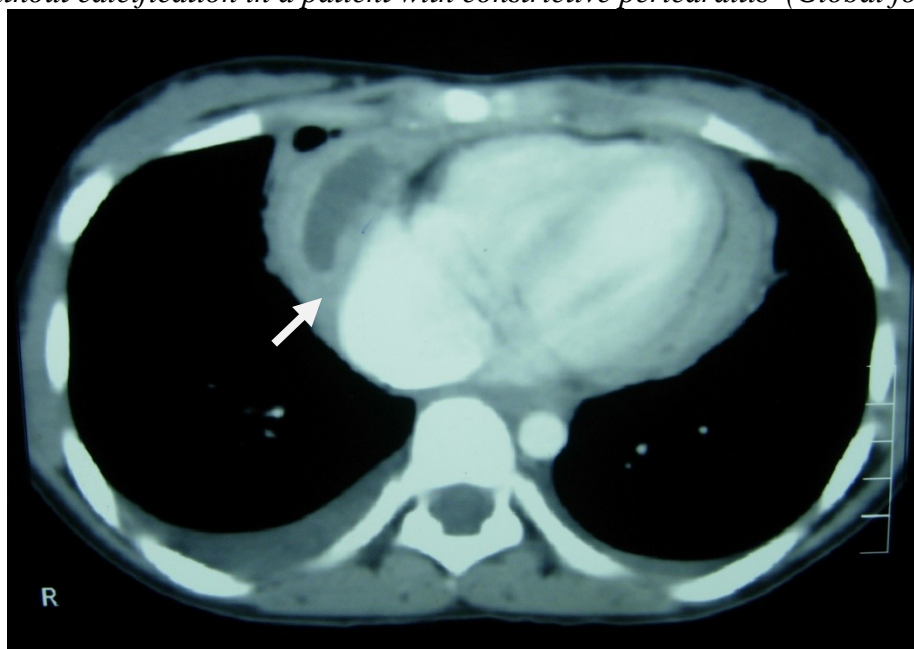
Constrictive pericarditis- Contrast enhanced CT chest showing markedly thickened pericardium especially around the Right Atrium.
